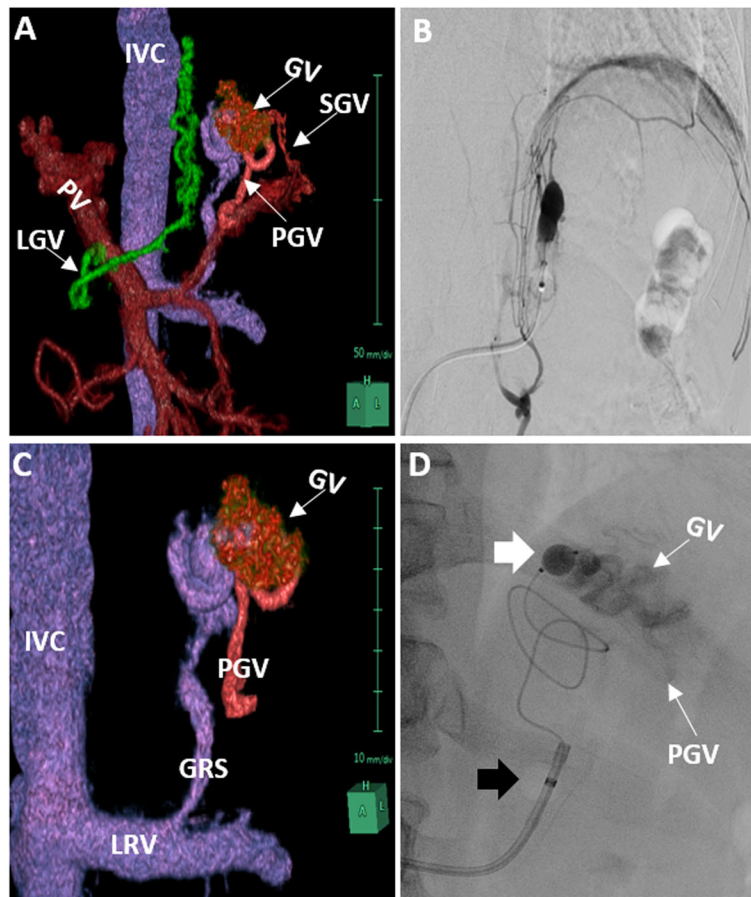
Superselektive BRTO technique. a Oblique volume rendering (VR) image obtained from pre-BRTO CE-CT portal phase images shows GV supplied by posterior gastric vein (PGV) and small short gastric vein (SGV) and drained by gastrorenal shunt (GRS). b DSA image during balloon occluded retrograde venography of the GRS shows multiple medium sized collateral veins without contrast opacification of the GV. c The same as VR image in a but magnified showing only GRS, GV and PGV as a reference image for image d. d Fluoroscopic image at the end of BRTO shows 9F balloon guiding catheter positioned at lower GRS (solid black arrow) while microballoon catheter (white solid arrow) was positioned at the junction point between GRS and GV. There is complete opacification of GV and part of PGV with EO1
